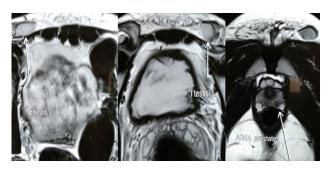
MRI showing bilateral undescended testes in inguinal canal, well developed prostate with no uterus
